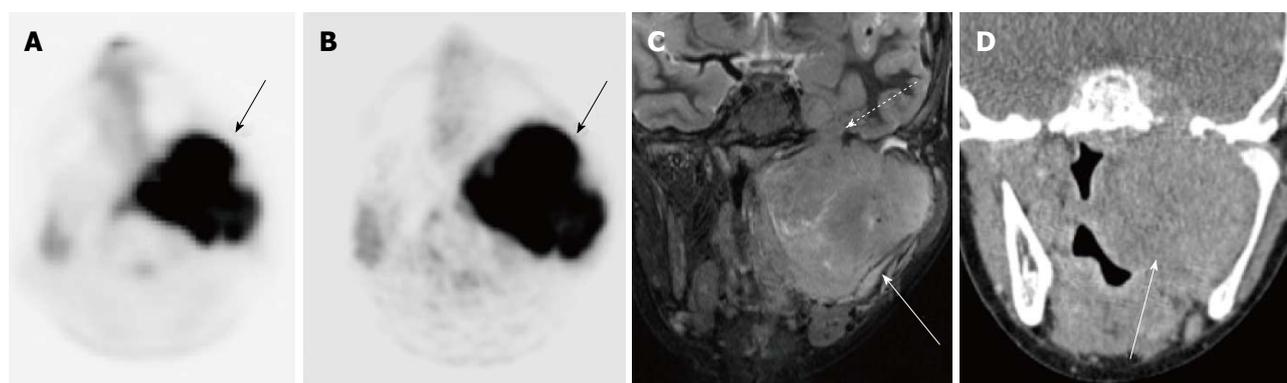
12-year-old male with rhabdomyosarcoma. Axial PET image from PET-MRI (A) shows intense FDG uptake in the left parapharyngeal region (black arrow). Axial PET image from PET-CT (B) shows similar uptake in the same region (black arrow). Coronal T2-weighted fat suppressed image from the MRI portion of the examination (C) clearly shows extent of tumor (white arrow) including perineural spread through foramen rotundum (white dashed arrow). Tumor is not as well delineated on this coronal CT image from the PET-CT examination (D) (white arrow). PET-MRI: Positron emission tomography-magnetic resonance imaging; CT: Computed tomography; FDG: Fluorodeoxyglucose.
